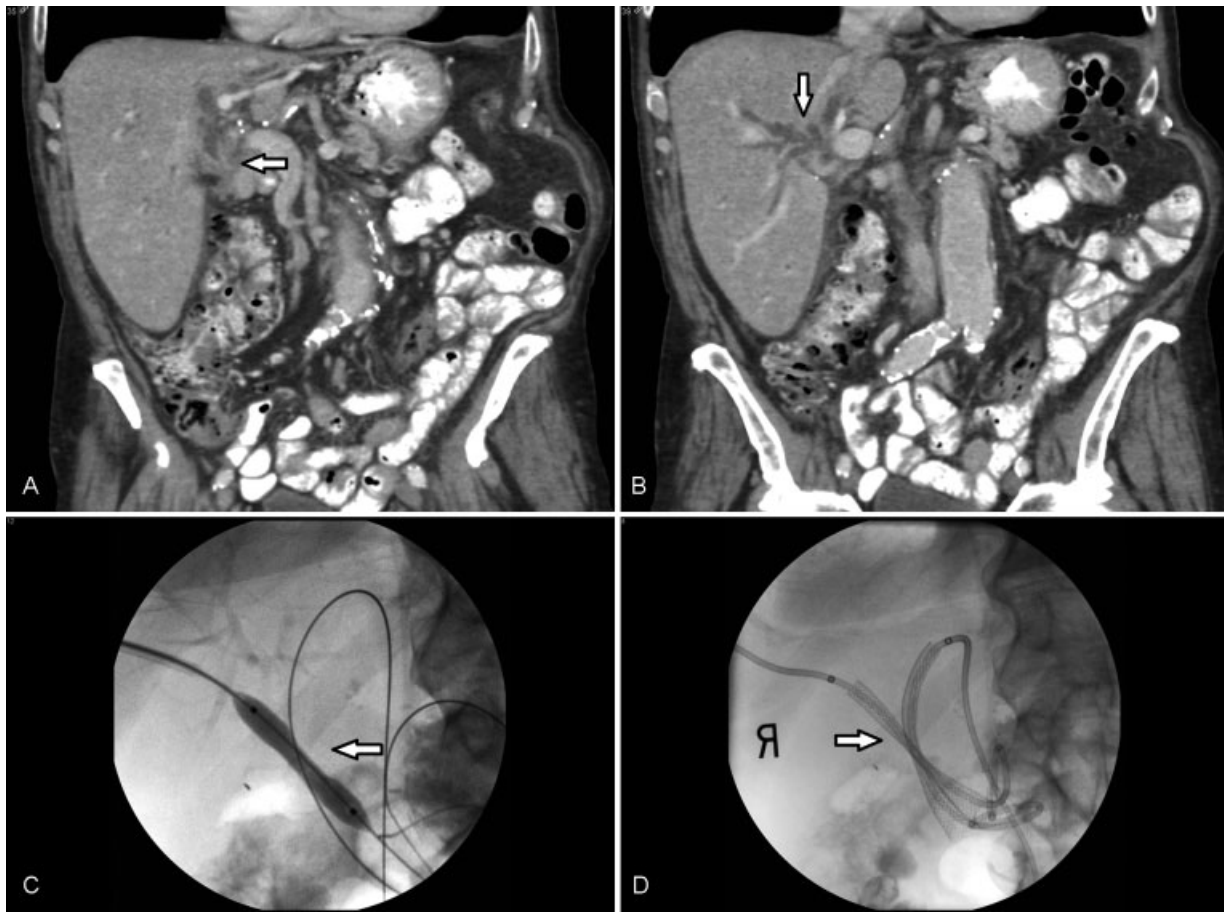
A 77-year-old male patient presents with jaundice, malaise, fatigue, and a 15 lb weight loss over 2 weeks. (A) Coronal gadolinium-enhanced CT in portal venous phase demonstrates smooth narrowing with some enhancement of the common bile duct at anastomosis (arrow), upstream dilatation of CBD, and intrahepatic biliary duct consistent with anastomotic stenosis due to bile duct adenocarcinoma. (B) Coronal gadolinium-enhanced CT in portal venous phase demonstrates upstream dilatation of CBD and intrahepatic biliary ducts (arrow). (C) Balloon dilatation of the malignant stricture (arrow) with a noncompliant 8 mm balloon. (D) Two crisscrossing (arrow) 10 mm × 6.8 cm covered metal biliary stents were placed via a percutaneous approach. CT, computed tomography.
